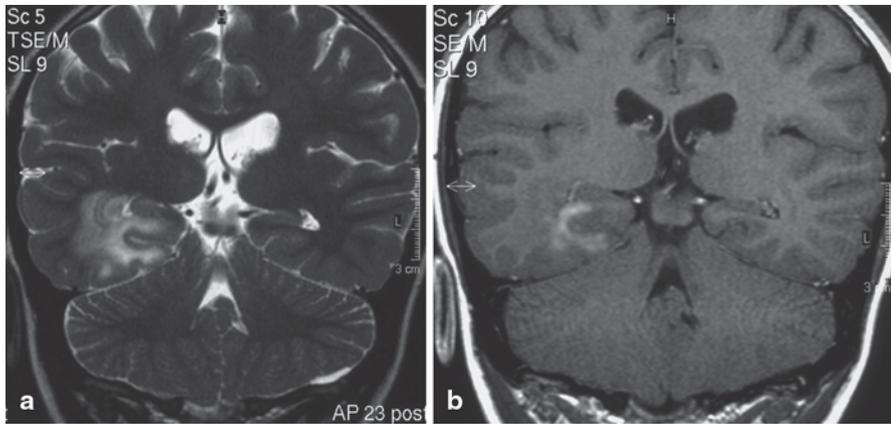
GG in a 10-year-old boy. a Coronal T2-weighted image. b Coronal Gd-enhanced T1-weighted image. Lesion involving the right mesial temporal structures, with mild swelling of the parahippocampal region, hyperintense on T2-weighted image (a). Following gadolinium injection the lesion enhances. No cystic components are present
